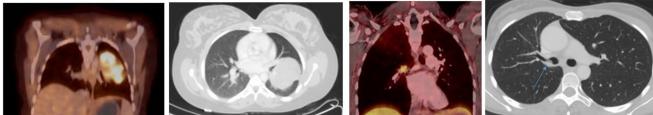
All computed tomography, positron emission tomography–computed tomography, and/or magnetic resonance imaging of all 4 cases. *PET*, Positron emission tomography; *CT*, computed tomography; *MRI*, magnetic resonance imaging.
